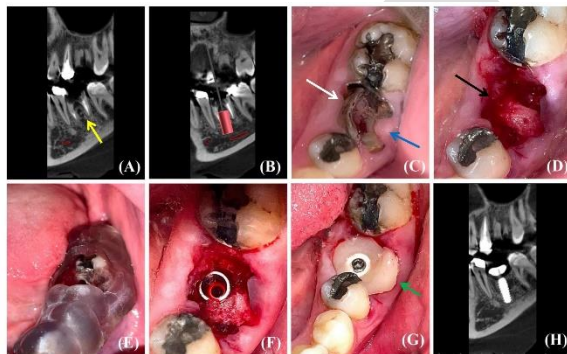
Computer-guided technique in immediately placed implant. (A), pre-operative CBCT x-ray showing severely damaged left mandibular first molar (yellow arrow). (B), CBCT X-ray showing virtual planned implant placed in the inter-radicular bone. (C), a pre-operative clinical photograph showing badly destroyed left mandibular first molar (white arrow) with gingival epulis (blue arrow). (D), a photograph showing the socket after extraction with adequate inter-radicular bone (black arrow). (E), a photograph showing the surgical guide inside patient mouth. (F), a photograph showing the implant inserted in the inter-radicular bone. (G), a photograph showing the custom-made healing abutment (green arrow). (H), a post-operative CBCT x-ray showing the implant placement in the inter-radicular bone like the treatment plan in (B).
